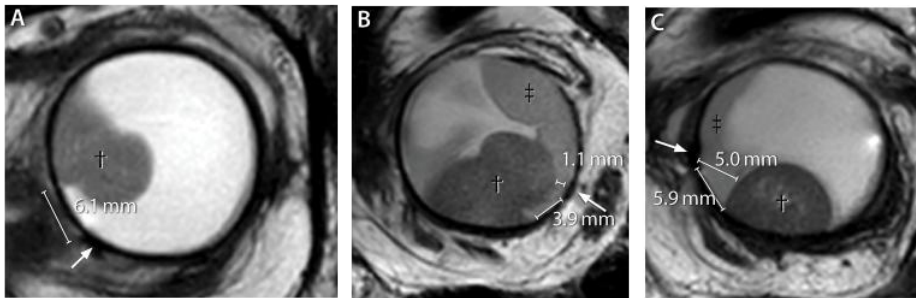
(A,B) The MRI shows a 6.1 mm (A) and 3.9 mm (B) distance between the marker (arrow) and the tumor base for these mushroom shaped UM. These complex tumor-retina relations, can however not easily be captured in a single distance measurement. (C) When a marker was positioned relatively distant from the tumor, the shortest distance to the tumor might not be to the tumor base, which was measured intraoperatively. In this figure the tumor was marked with a dagger and the retinal detachment with a double dagger.
